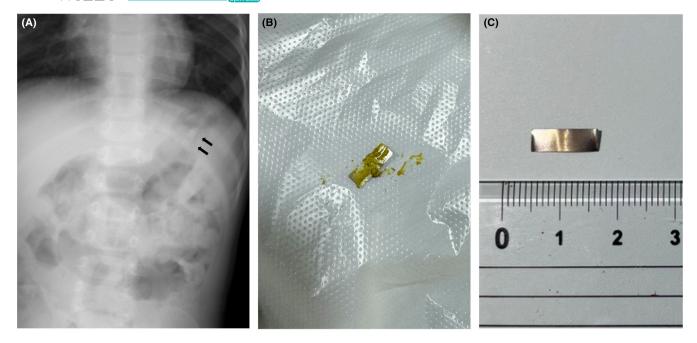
(A) Abdominal X-ray findings of the first patient. A metal object was found in the stomach. (B, C) Two days after the accidental ingestion, the metal foreign object was excreted in the stool. Black arrows; metallic foreign bodies.
